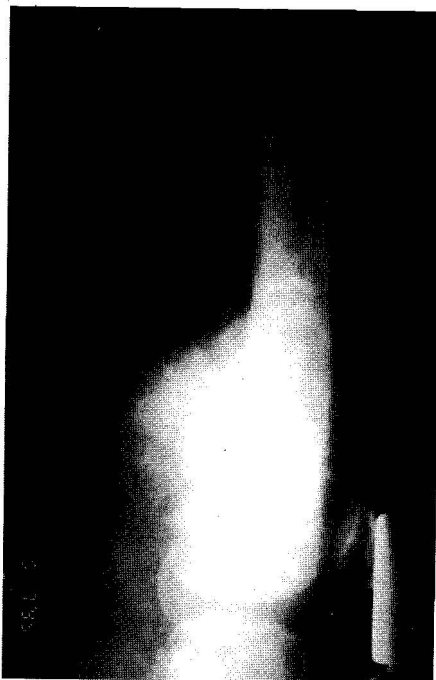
Preoperative x-rays showing sun-ray appearance and condmans triangle in osteosarcoma of the distal femur.
